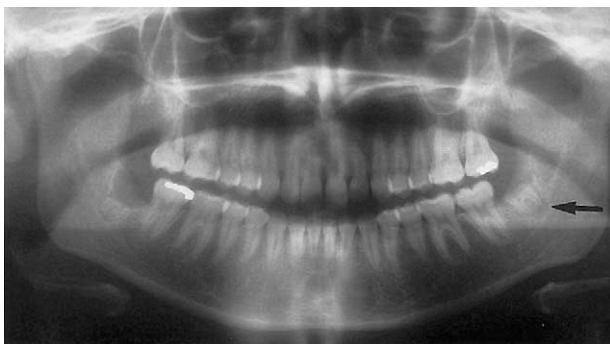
A, Radiograph immediately postoperatively showing position of retained root fragment. B, Appearance 6 months later as the roots of the lower right third molar erupted into the oral cavity, necessitating removal.
